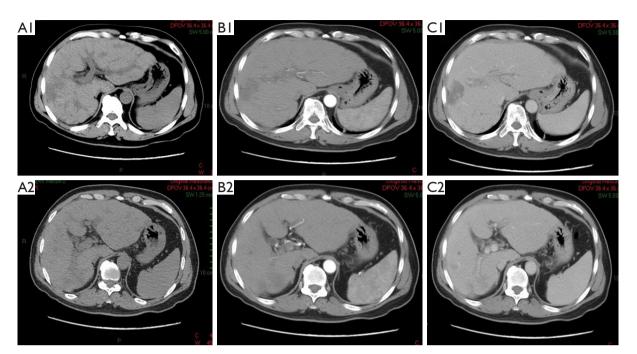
CT images after 4 months of follow-up after 6 cycles of HAIC. A new tumor appeared in the (A1,A2) unenhanced CT scanning phase, the liver postcontrast CT image of the (B1,B2) arterial phase and (C1,C2) portal venous phase. CT, computed tomography; HAIC, hepatic arterial infusion chemotherapy.
